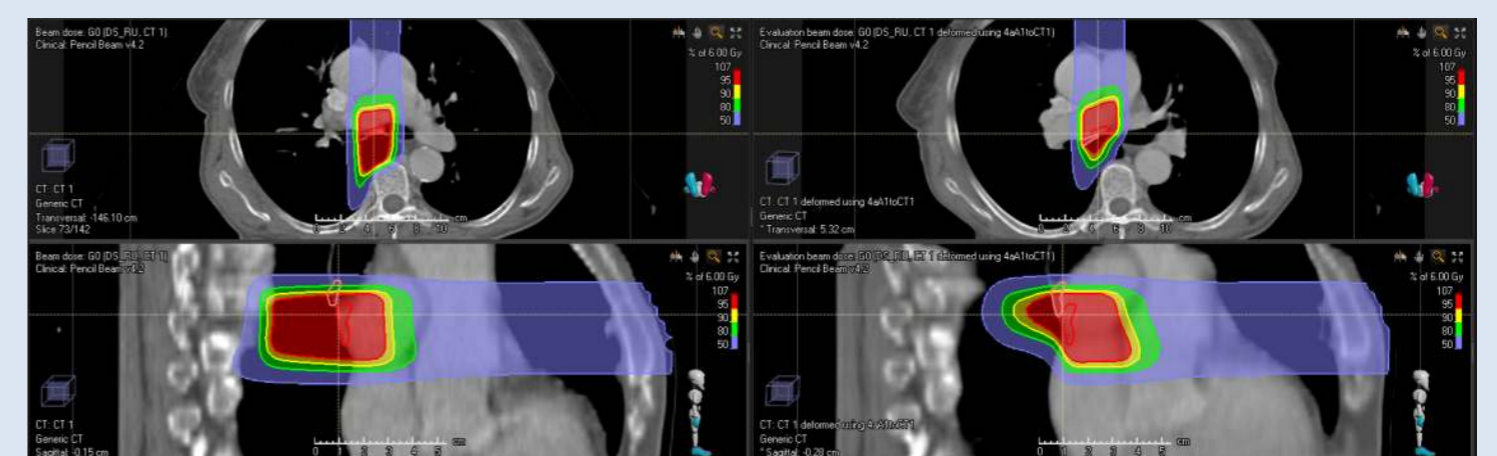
Above shows an example of dose coverage comparison for Pat4 and 4th Fraction CBCT as compared to PCT for a single field from 0° Gantry position.
